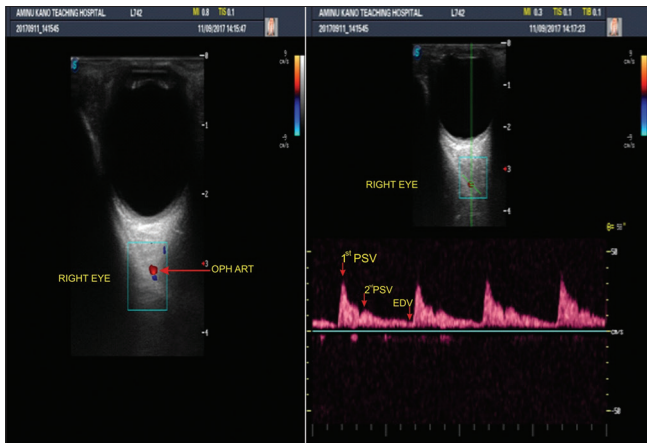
Doppler ultrasound image showing the ophthalmic artery and its spectral waveform in a normal subject. PSV = Peak Systolic velocity, EDV = End Diastolic Velocity, Oph Art = Ophthalmic artery
